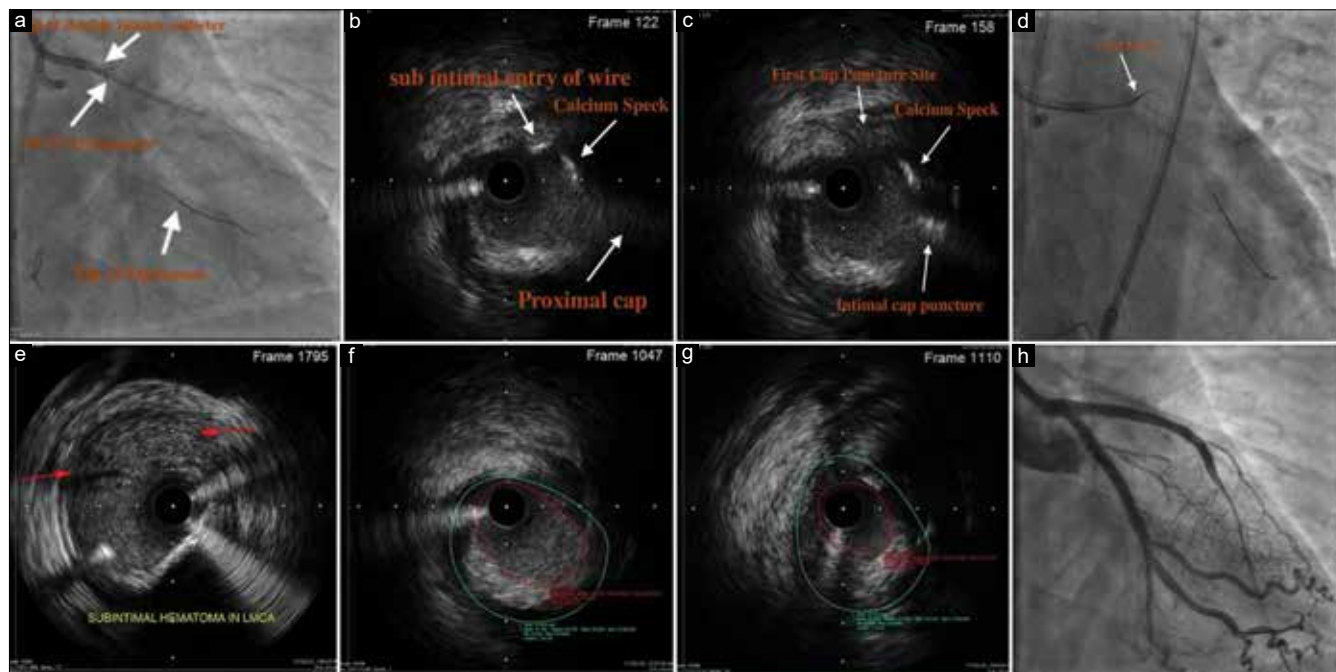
(a) Intravascular ultrasound (IVUS)-guided cap puncture - IVUS catheter, (b) IVUS showing antegrade wire entry at subintimal plane away from cap, (c) IVUS - Hornet 10 in proximal cap, (d) Fluro-Hornet 10 in proximal cap, (e) IVUS - Intramural hematoma compressing true lumen, (f) Ostial left circumflex artery (LCX) minimum lumen area (MLA) in IVUS before LM TO left anterior descending artery (LAD) stent (MLA: 5–6 mm²), (g) Ostial LCX MLA after left main coronary artery to LAD stent followed by POT (MLA: 2–3 mm²), (h) Final angiogram result
